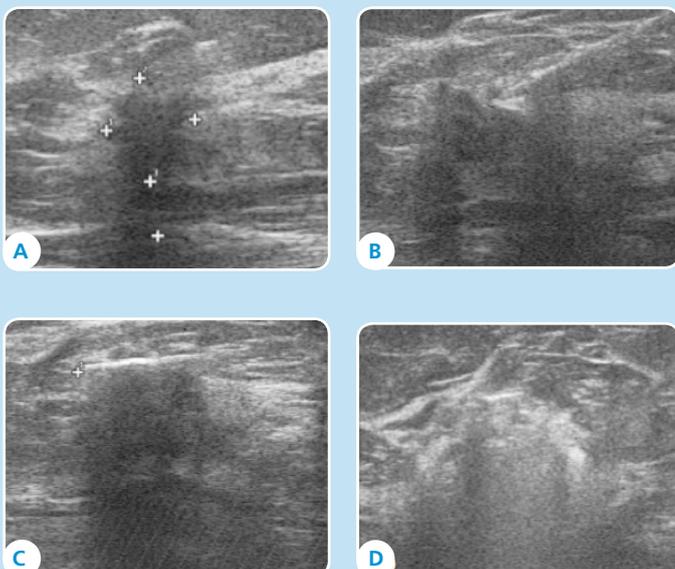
Ultrasound-guided LITT of a 15 mm invasive ductal carcinoma: A) Lesion to treat. B) Insertion of the needle inside the lesion. C) Positioning of the needle and the laser fiber. D) Sonographic appearance of the lesion after the treatment.
